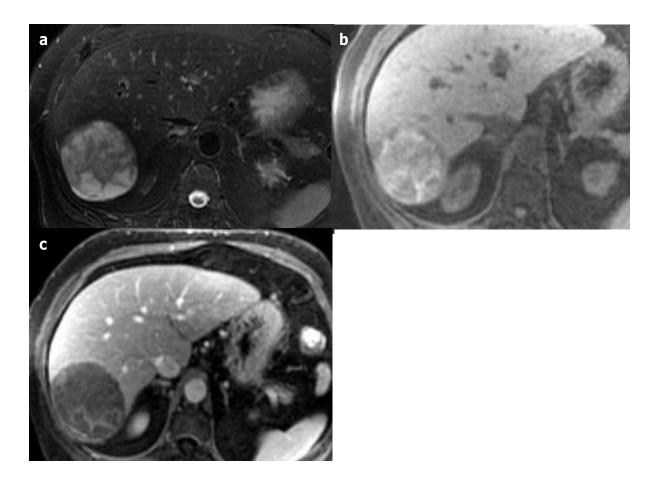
Haemorrhagic cyst at recent stage in a 66-year-old female patient. (a) Axial T2-weighted magnetic resonance imaging shows heterogeneous hyperintensity and (b and c) Axial T1 fat-sat-weighted magnetic resonance imaging shows a lesion spontaneously hyperintense with no enhancement after gadolinium-chelate injection.
